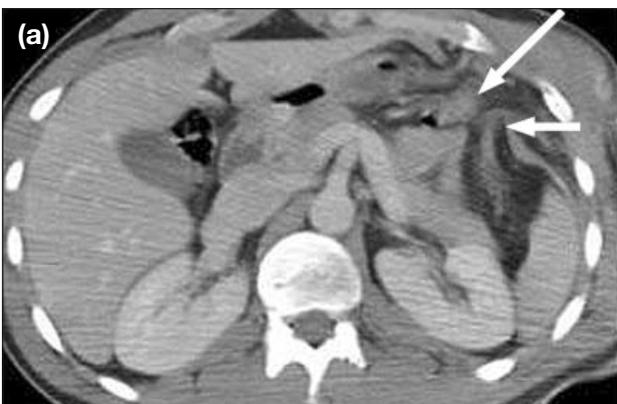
Left diaphragm rupture following blunt injury. Axial computed tomography scan shows (a) gastric herniation (long arrow) through a ruptured diaphragm (short arrow) — this is known as the ‘collar sign’; and (b) vascular contrast material extravasation in the chest wall (long arrow) with soft tissue haematoma (short arrow).
